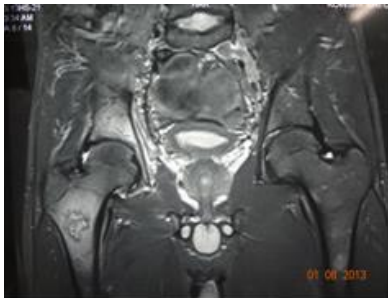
MRI of hip: revealed an osteolytic lesion in the right iliac bone with extension to acetabular roof, mild joint effusion in hip joint, a heterogeneous lesion in the right femoral metaphysis and bone marrow invasion
